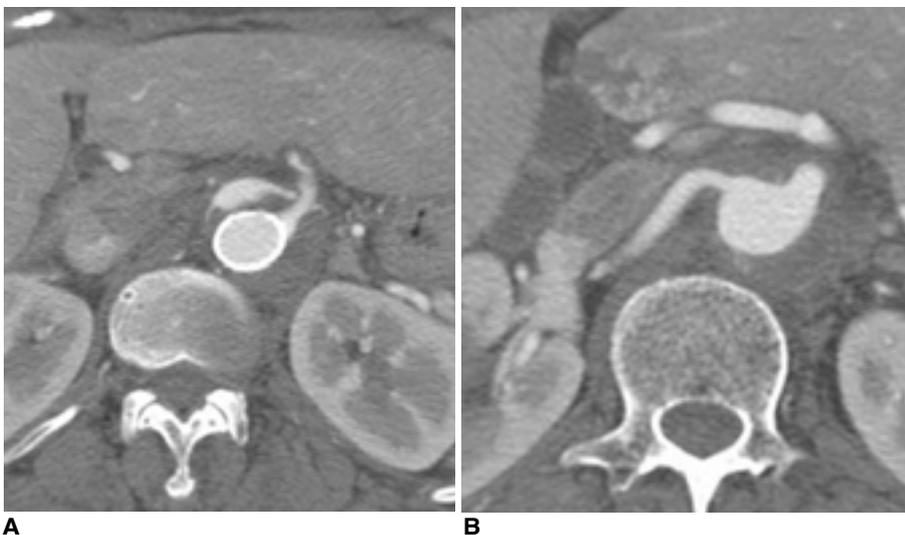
A, B. On follow-up CT scan 10 days after aortic stent insertion, the stent is widely patent and compression of the orifices of celiac trunk and right renal artery is relieved.
